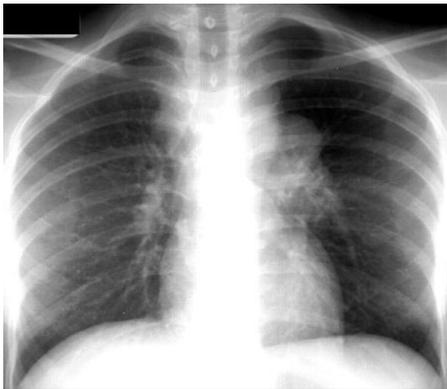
Lymphadenopathy in a patient with primary tuberculosis. Chest radiograph shows a bulky left hilum and a right paratracheal mass.
